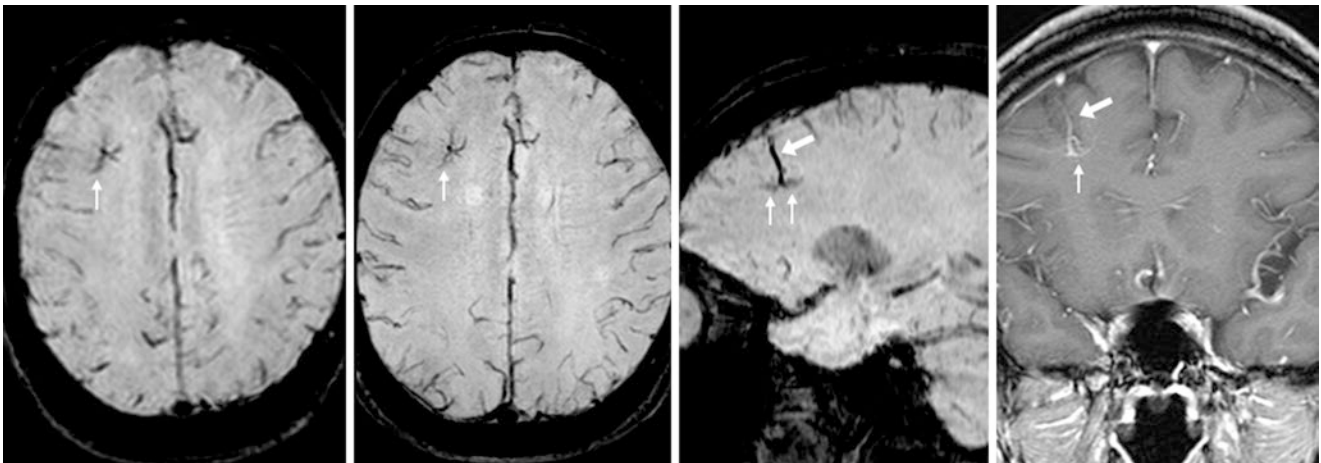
A 48 year old with vertigo, in whom a 1.5T MRI with SWI (*left*) demonstrated a DVA's caput of hazy vessels (*thin arrows*), which was unchanged on a 1.5T MRI with SWI 1 year later (*left middle*).
